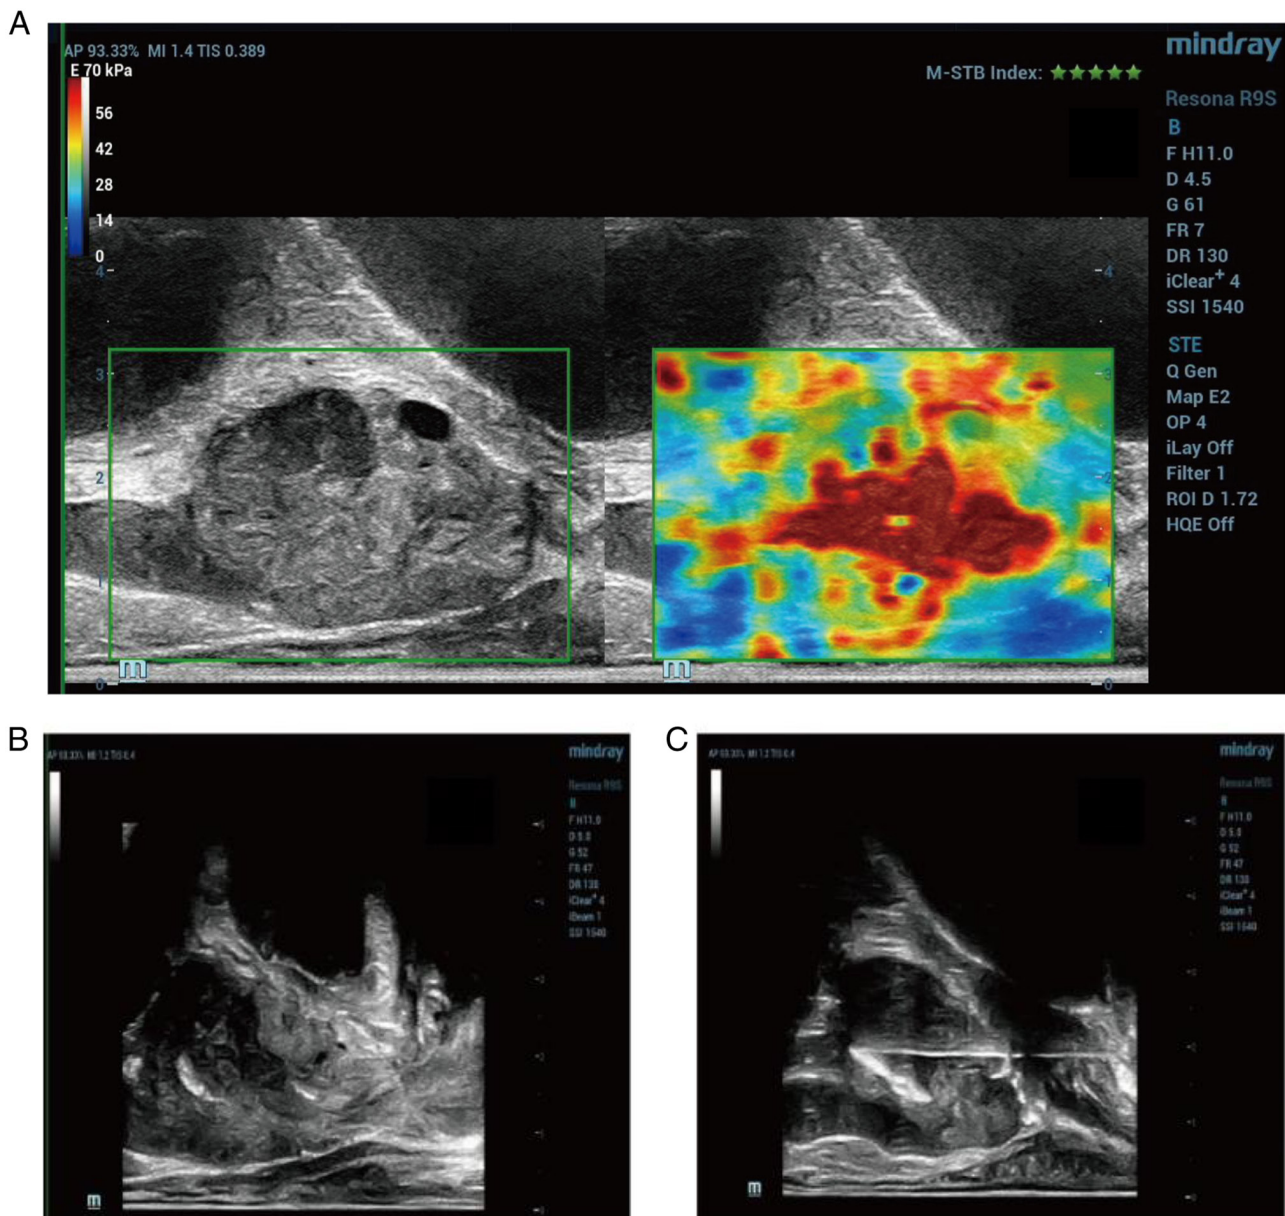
TP biopsy imaging. (A) TP ultrasound elastography image. (B) TP ultrasound two-dimensional image. (C) TP prostate biopsy image. TP, transperineal prostate.
